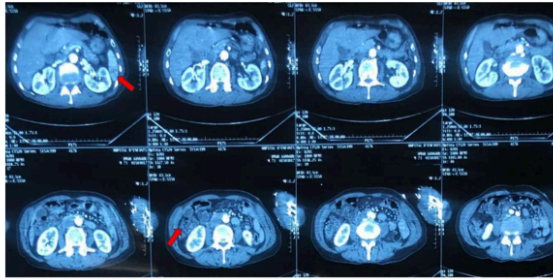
Thoracoabdominal computed tomography (CT) scan revealing multiple splenic and renal infarctions
